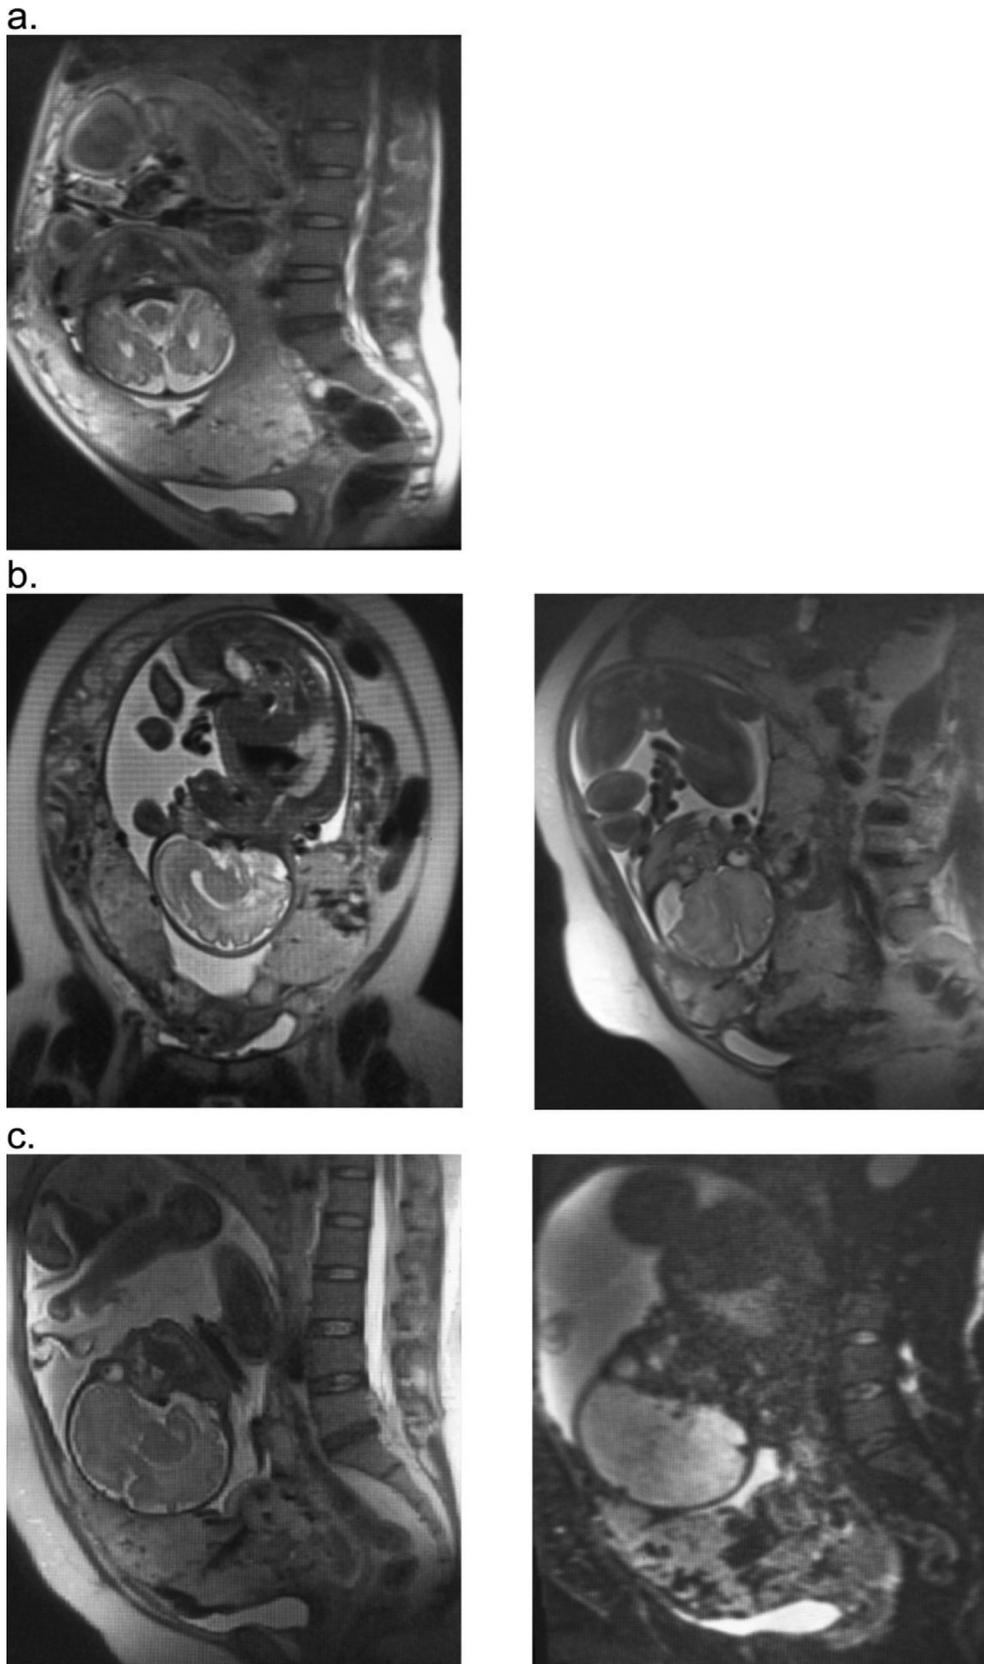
The characteristic MR images in MAP. (A) Placenta previa with anteroinferior placenta increta, in which uterine preservation surgery will be done; the surgery is typically effective. (B) Placenta previa with a large area and massive placenta increta, for which we will prepare to perform a hysterectomy for all eventualities. In case of a life-threatening hemorrhage, hysterectomy will be performed without hesitation. If the PABO and the tourniquet obstruct the blood supply and hemostasis is reached, hysterectomy will not be performed. (C) Placenta previa that has penetrated the posterior bladder wall. In these cases, we prepare to perform a hysterectomy package if it becomes necessary. If the PABO and the tourniquet obstruct the blood supply and hemostasis is reached, hysterectomy will not be performed.
